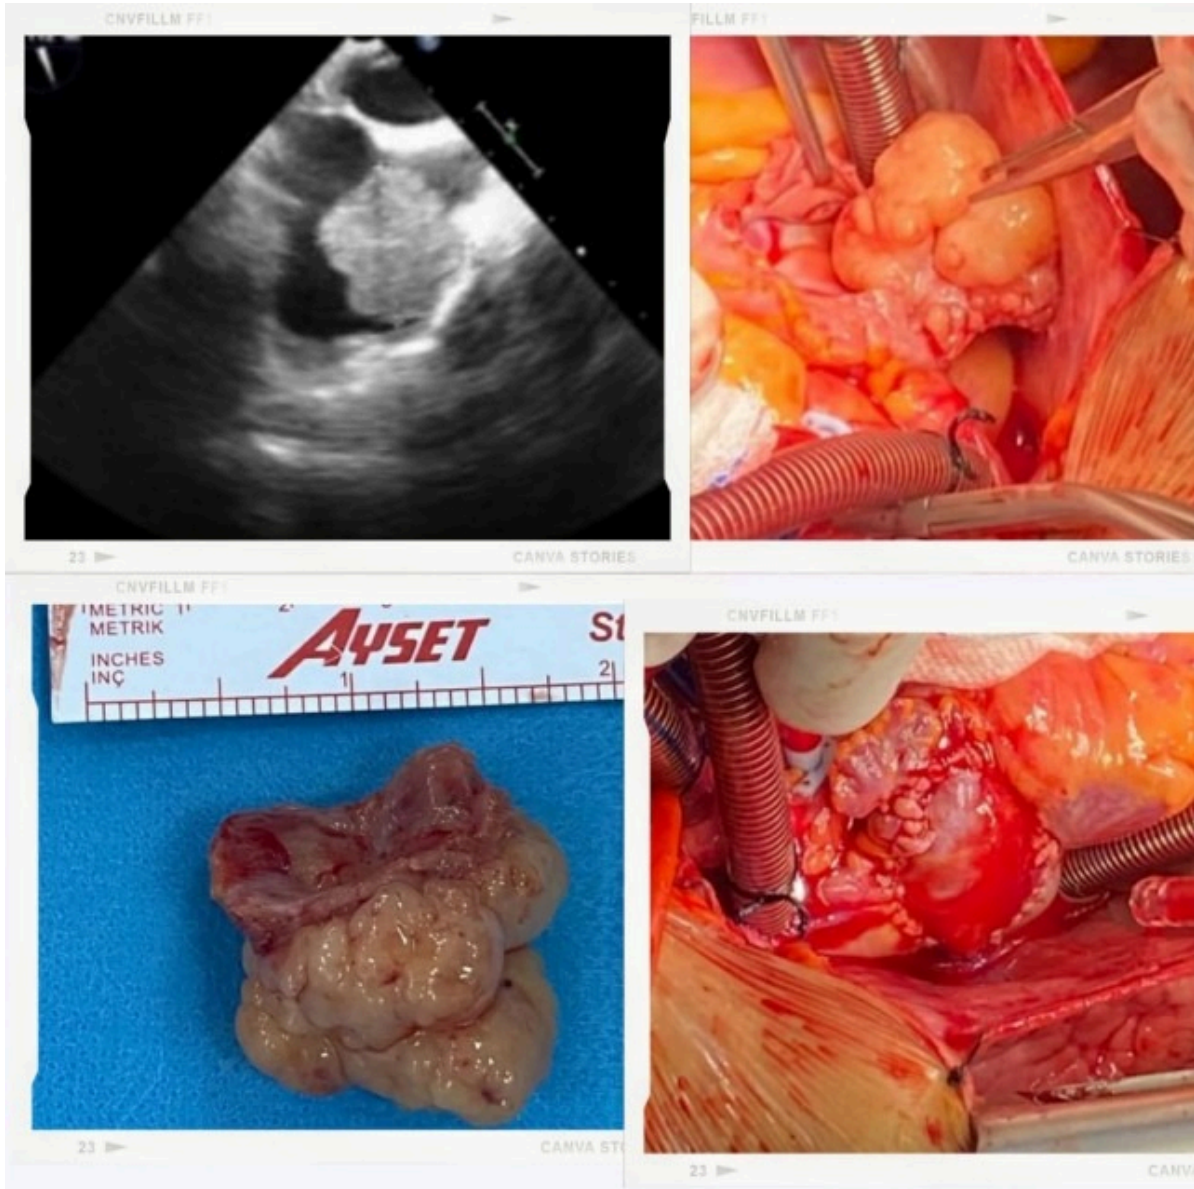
Echocardiographic image of the metastasis and also intraoperative image of tumor and the pericardial patch.
